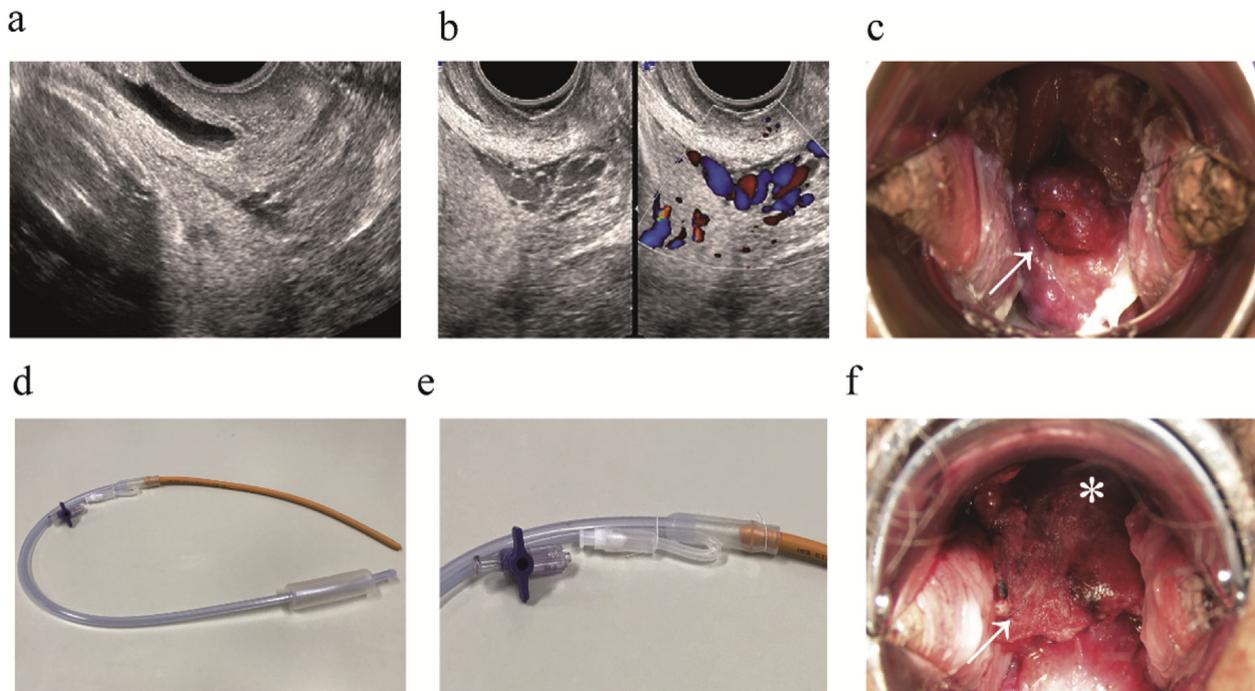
Transvaginal sonography and speculum examination results. (a) Transvaginal sonography at 35-weeks' gestation showing no intracervical vessel. (b) Transvaginal color Doppler sonography showing the large intracervical vessel. (c) Macroscopic view of the cervical varix. White arrow indicates the cervical varix. (d, e) Image of our modified Matsubara Nelaton method. The type of Nelaton rubber tube and its connections have been modified from the original method because of unavailability of the original Nelaton tube at our hospital. The no. 13 Nelaton rubber tube was used and connected to the blood drainage port of the Bakri balloon. (f) The view after removing the Bakri balloon. White arrow indicates the posterior lip of external os of the uterus. Disappearance of the cervical varix is marked by a white asterisk. It remains unknown whether the varix was ruptured. Previous reports stated that cervical varix may have immediately regressed after delivery.
